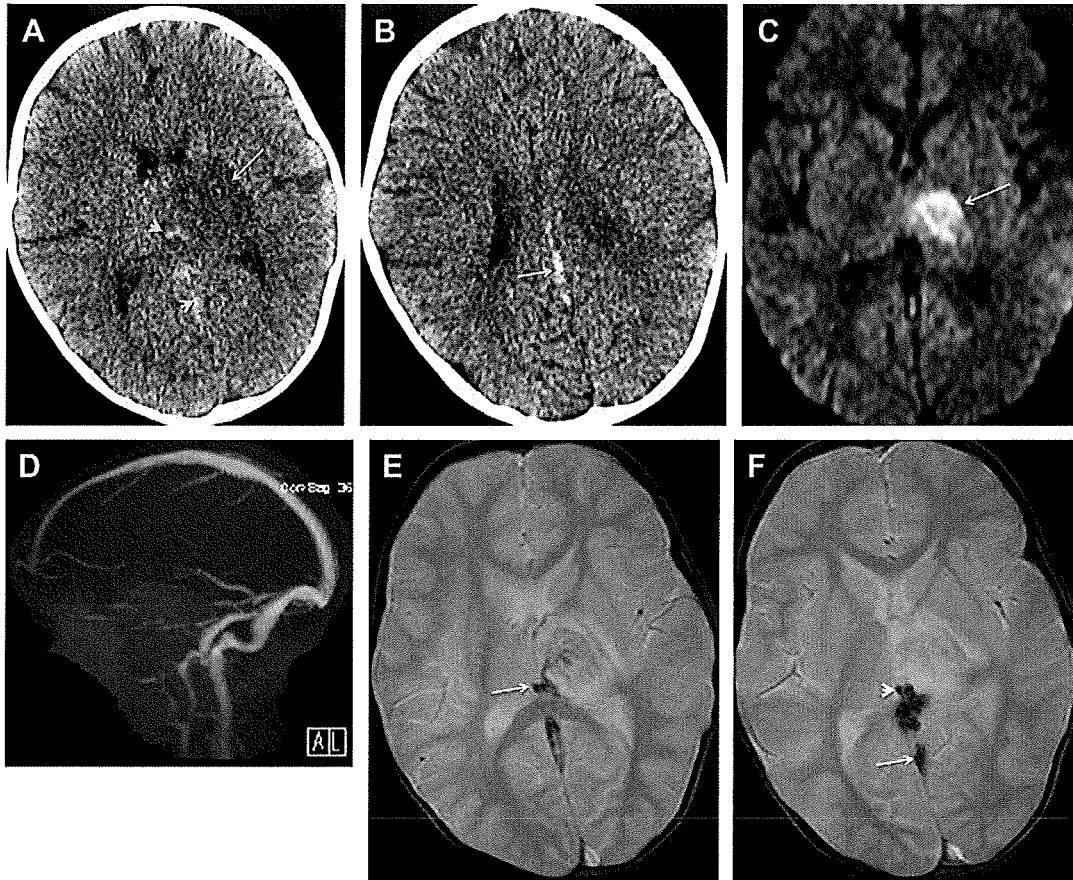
Deep venous thrombosis with thalamic and basal ganglia infarcts. Axial noncontrast CT images (A, B) show confluent hypoattenuation in the left thalamus and left basal ganglia (arrow in A) as well as subtle hyperattenuation along the deep veins (arrowheads on A and arrow on B), suggesting thrombosis. Axial diffusion-weighted image (C) shows restricted diffusion in the left thalamus (arrow) consistent with acute infarction. Maximum intensity projection MR venographic image (D) demonstrates lack of flow-related enhancement in the internal cerebral veins, vein of Galen, and straight sinus, consistent with thrombosis. Axial gradient echo images (E, F) demonstrate blooming of susceptibility artifact within the deep veins (arrow in E and arrowhead in F) and straight sinus (arrow in F) caused by deep venous thrombosis.
